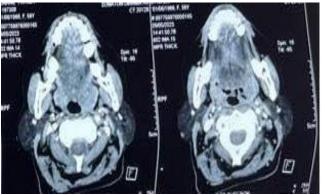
Cervical CT axial section: Tumor of the left palatine tonsil
